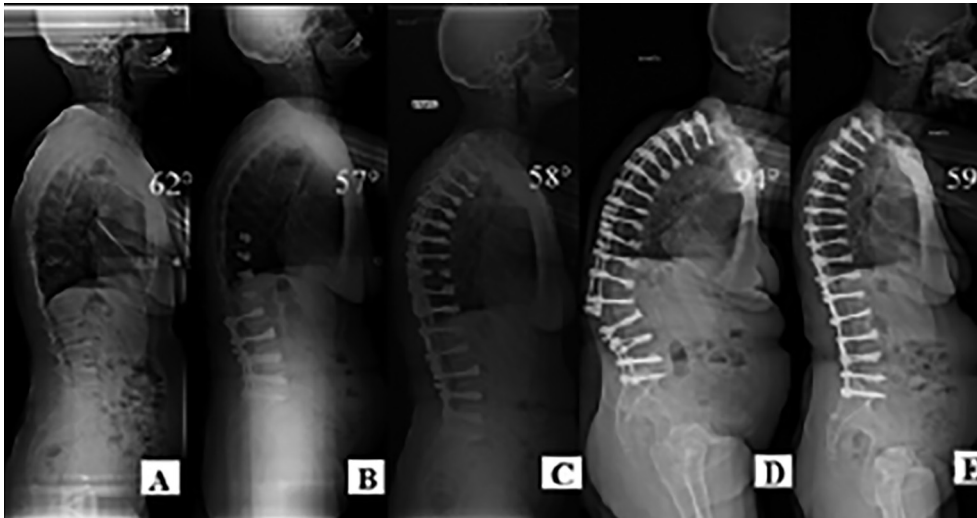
a) Preoperative standing lateral spine radiograph; b-c) Early postoperative standing lateral spine radiograph; d) Rod breakage due to pseudoarthrosis at one-year follow-up; and e) Eighteen-month follow-up after revision surgery
